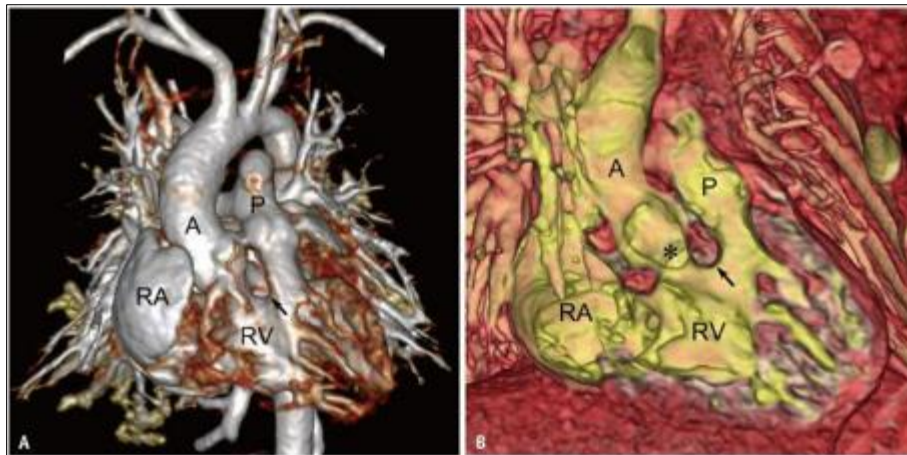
Double outlet RV with subaortic VSD in a neonate. A, B. Standard (A) and transparent-lumen (B) volume-rendered CT images show that P is exclusively connected to the RV, and more than half of the A is connected to the RV. The outlet septum (arrows) is fused with the anterior margin of the subaortic VSD (asterisk). A = ascending aorta, P = pulmonary artery, RA = right atrium, RV = right ventricle, VSD = ventricular septal defect
